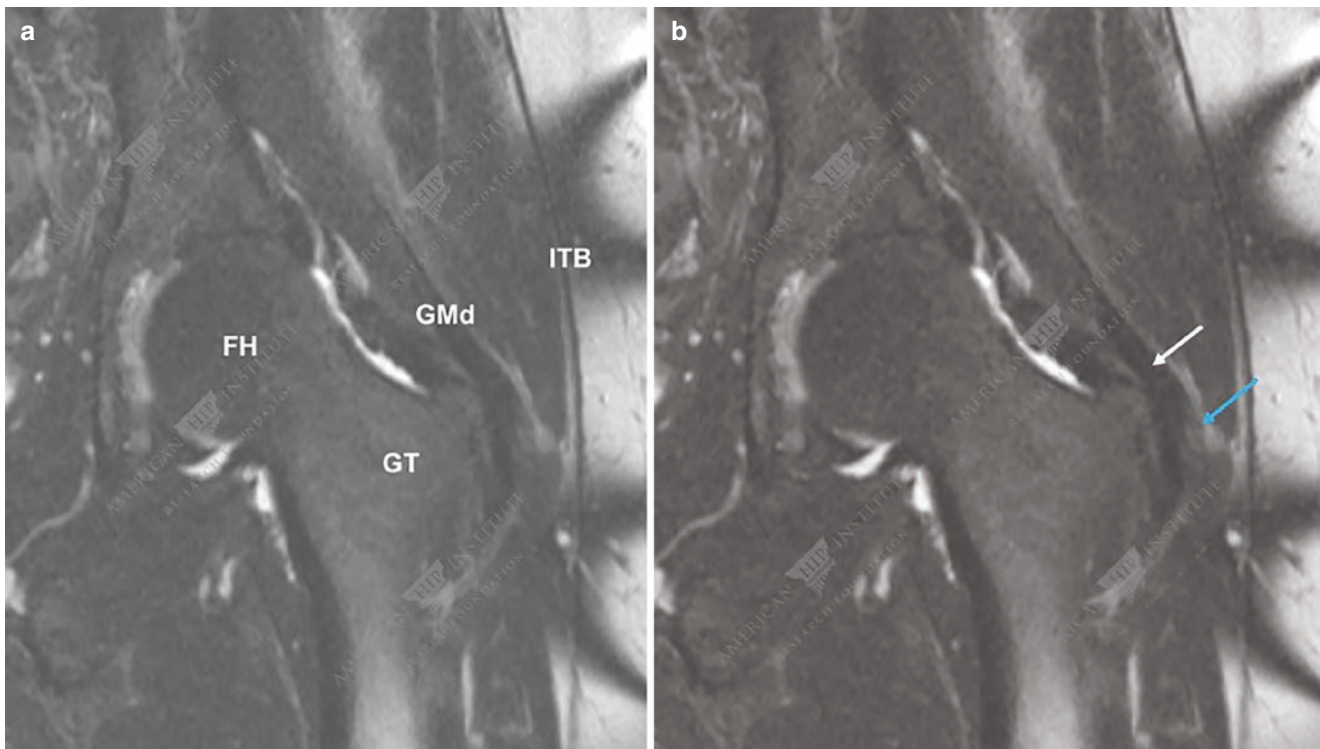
(a) Coronal fat-saturated T2-weighted image. The anatomic structures being scrutinized: *GM* gluteus medius, *FH* femoral head, *GT* greater trochanter, *TB* trochanteric bursa, *ITB* iliotibial band. (b) Mild signal heterogeneity can be seen at the insertion of the abductor tendons
